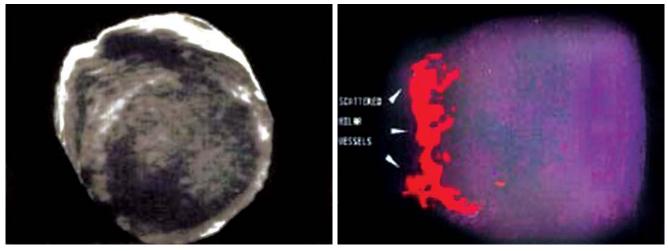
Three-dimensional scan of an ovarian endometrioma. Fig. 19: Scattered vascularity at the level of the ovarian hilus depicted Homogenous high level internal echoes are visualized by this technique by three-dimensional power Doppler is typical of ovarian endometrioma
